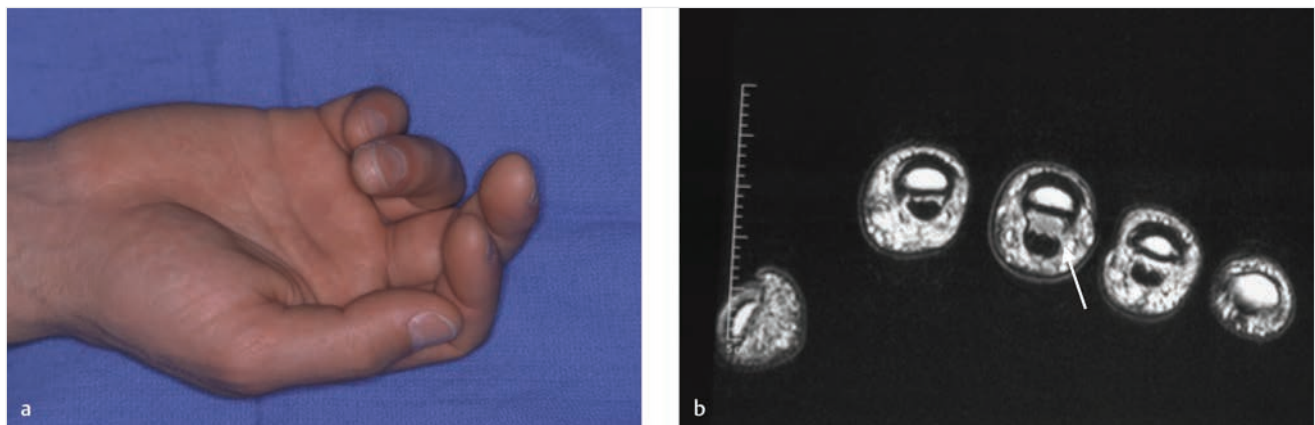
(a) Clinical view 2 months after trigger release of the right long finger. (b) View of the right hand on MRI scan indicating volar displacement of the flexor tendons (away from the proximal phalanx) of the long finger (white arrow).
